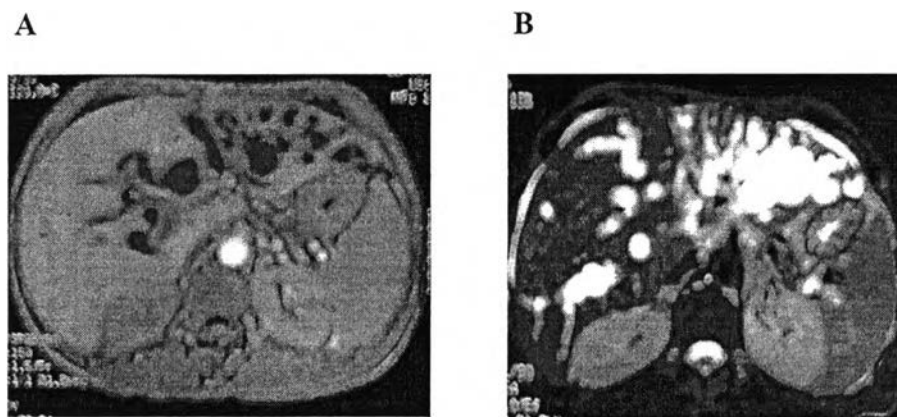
Magnetic resonance imaging (MRI) : MRI of hepatobiliary system in T1 weighted(A) and T2 weighted images(B).
